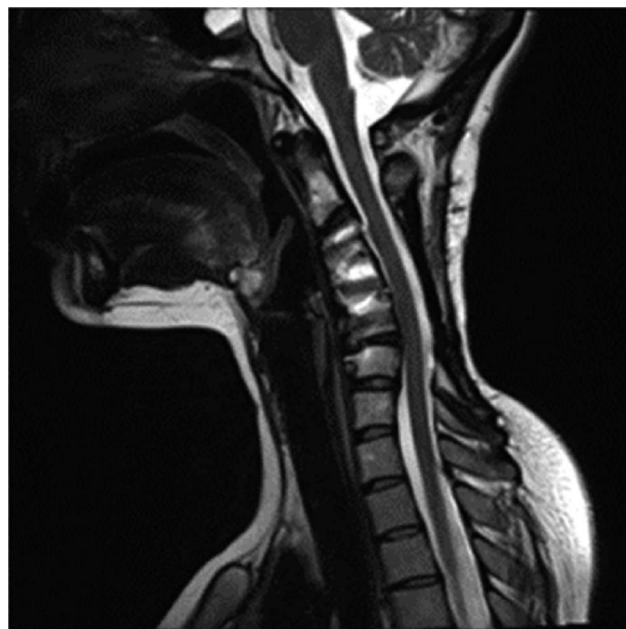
Sagittal view of cervical spine magnetic resonance imaging with contrast 20 years following en bloc resection of cervical chordoma.
